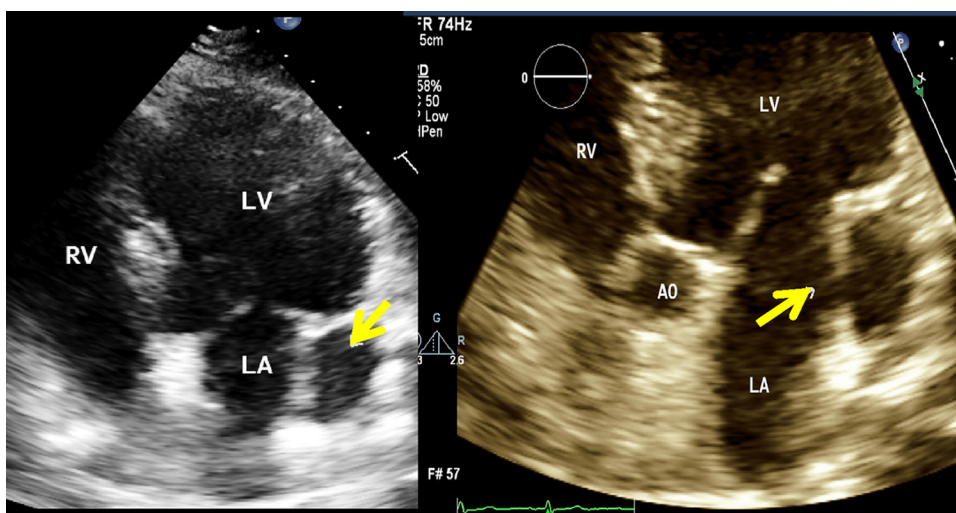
Trans-thoracic echocardiographic 4-chamber and 5-chamber views showing an additional chamber within the left atrium just above posterolateral mitral annulus (arrows). Yellow arrow in right image points toward the communicating channel.
